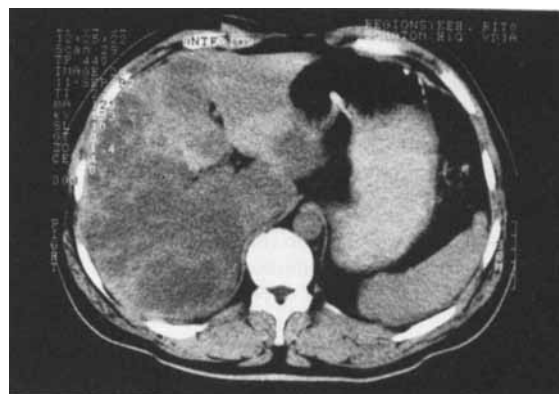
CT scan after 6 months of adjuvant chemotherapy (5-FU/levamisole) revealing fat infiltration imitating liver metastases.
